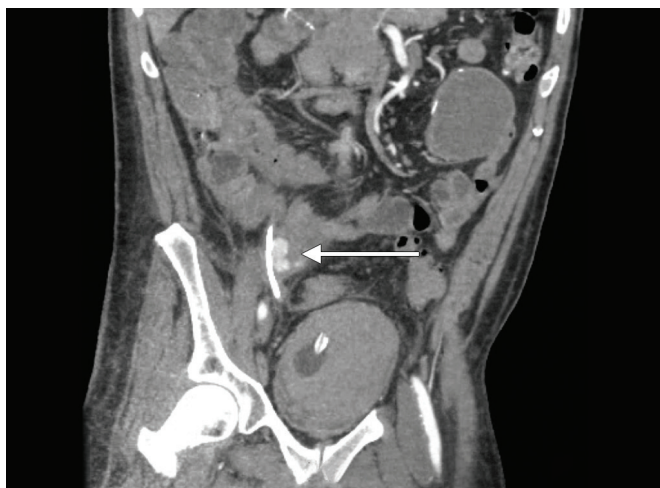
CT IVP on POD 48 showing the pseudoaneurysm of the right external iliac artery with the right ureter with extravasation
